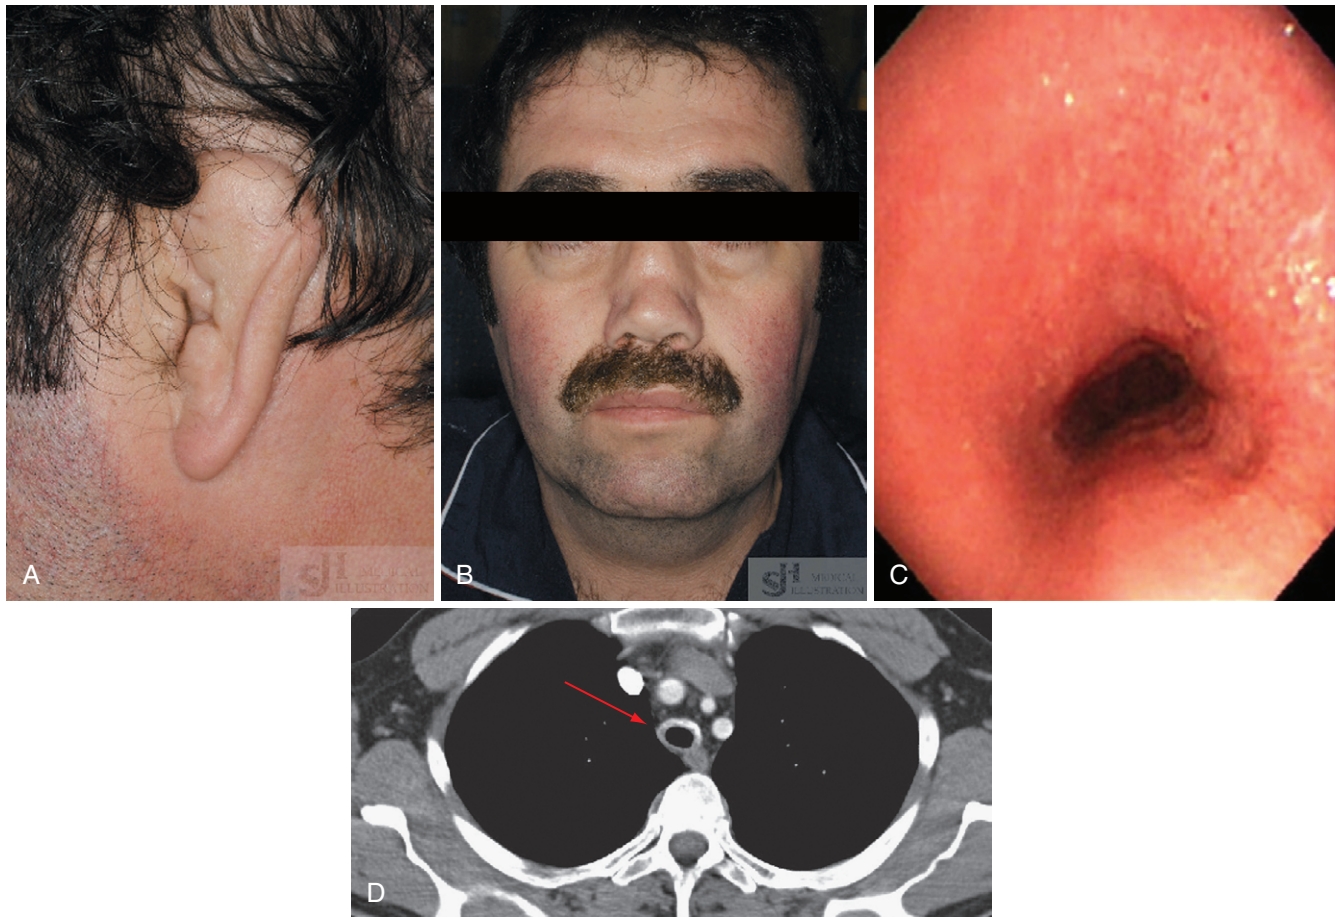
A, Chronic changes of relapsing polychondritis (RPC) in the cartilaginous upper two-thirds of the ear, evident after repeated episodes of inflammation in this area. B, Saddle nose deformity, developed after episodic nasal chondritis. C, Bronchoscopy findings demonstrating mucosal hyperemia, edema with lack of normal detail of tracheal cartilaginous rings, and flattening of the trachea. D, Computed tomography thorax with arrow demonstrating tracheal flattening and calcification in a patient with RPC. (A and B, Courtesy Mr. Anthony Edwards, clinical photographer, St. James's Hospital, Dublin 8. C and D, Courtesy Dr. Finbarr O'Connell, consultant pulmonologist, St. James's Hospital, Dublin 8.)
